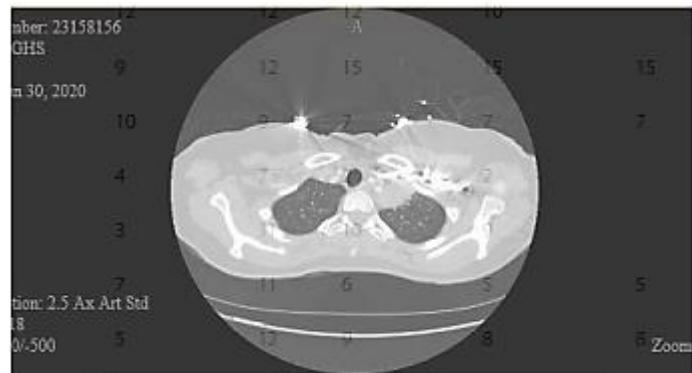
CT image of lung
